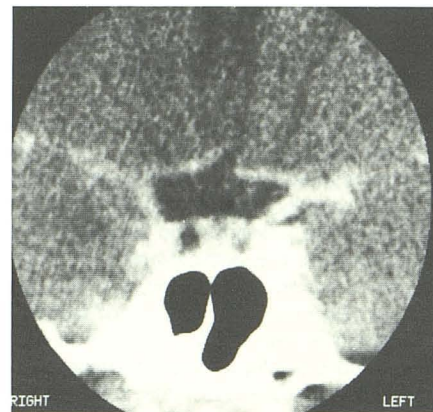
CT scan of two coexisting microprolactinomas, subsequently confirmed at surgery.
